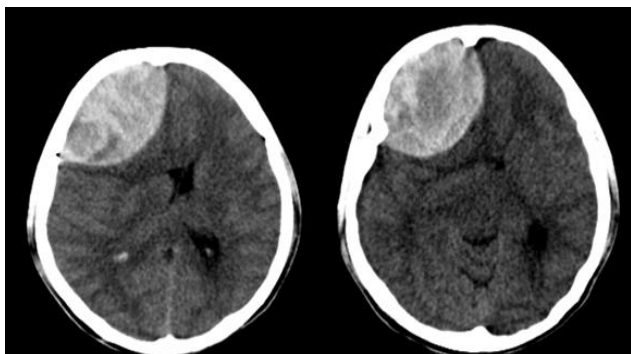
Brain CT scan of patient after hemodialysis. [↑](#)
